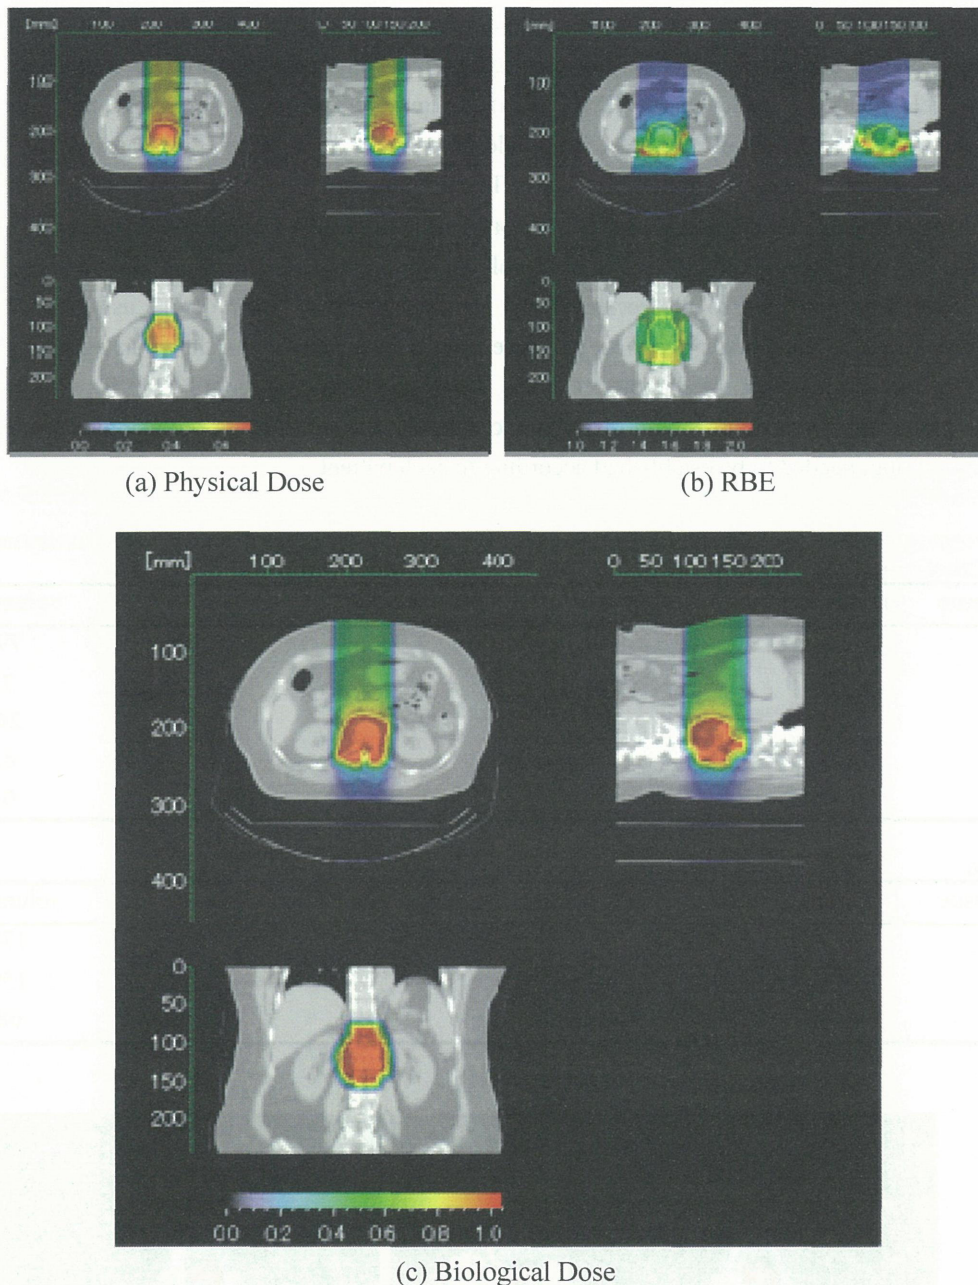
CT images with color-wash display of (a) physical dose, (b) RBE and (c) biological dose distribution. The PTV is identified with yellow curve on each CT image.
